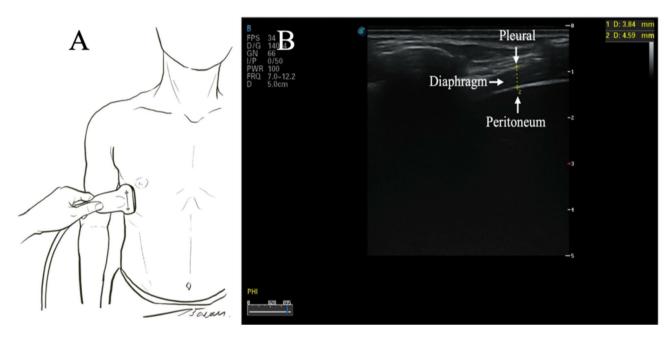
(A) Position the B-mode ultrasound transducer (B) Ultrasound images were obtained over this area.
